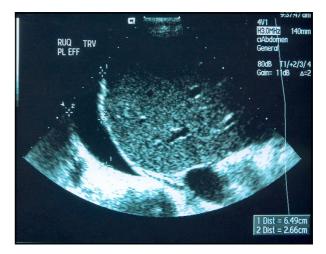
The chest ultrasonography.
